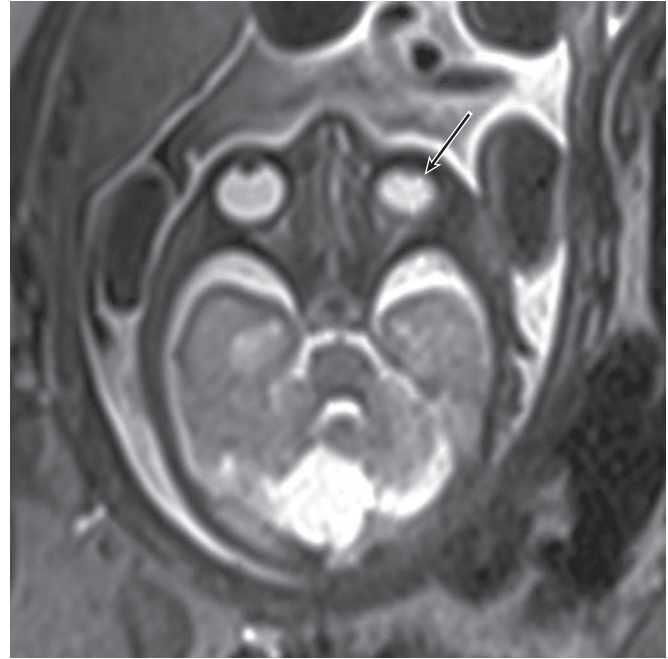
Aicardi syndrome. Fetal MRI image demonstrates unilateral microphthalmia (arrow).
